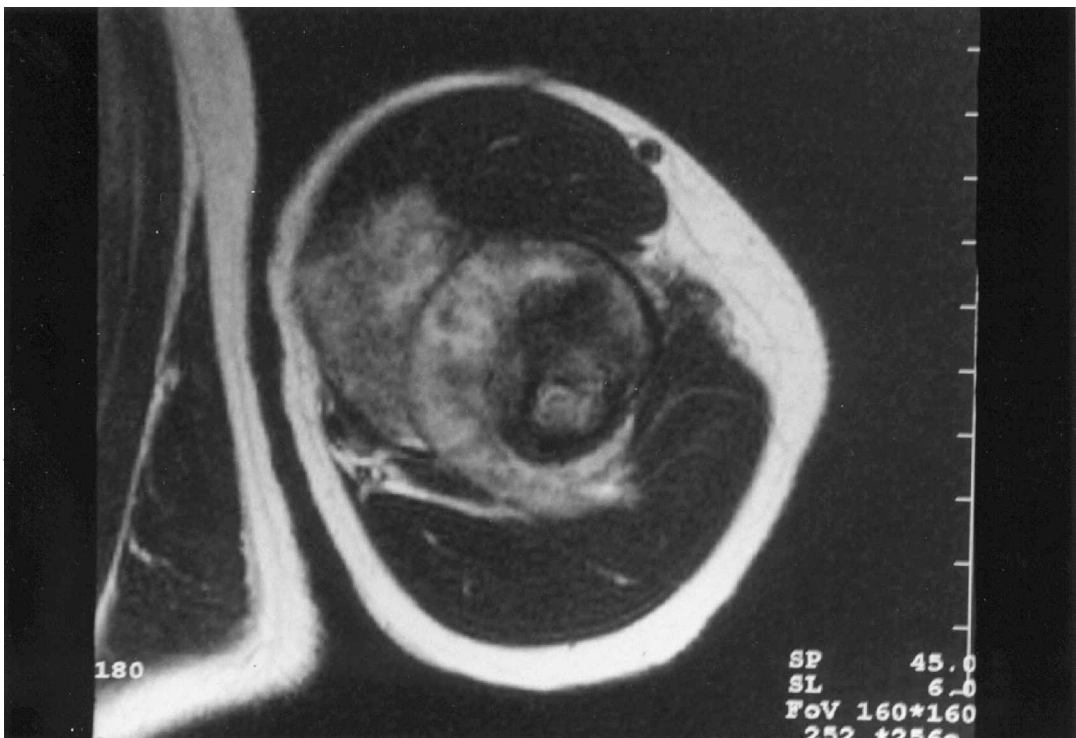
(a) Plain radiograph of a humerus showing many typical features of a periosteal osteosarcoma in the diaphyseal region. (b) Magnetic resonance image of the same tumour, showing eccentric epicentre and near encirclement.
